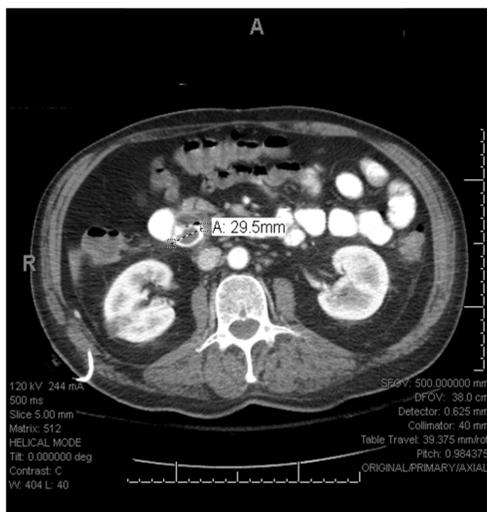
CT Scan: -Day 11
